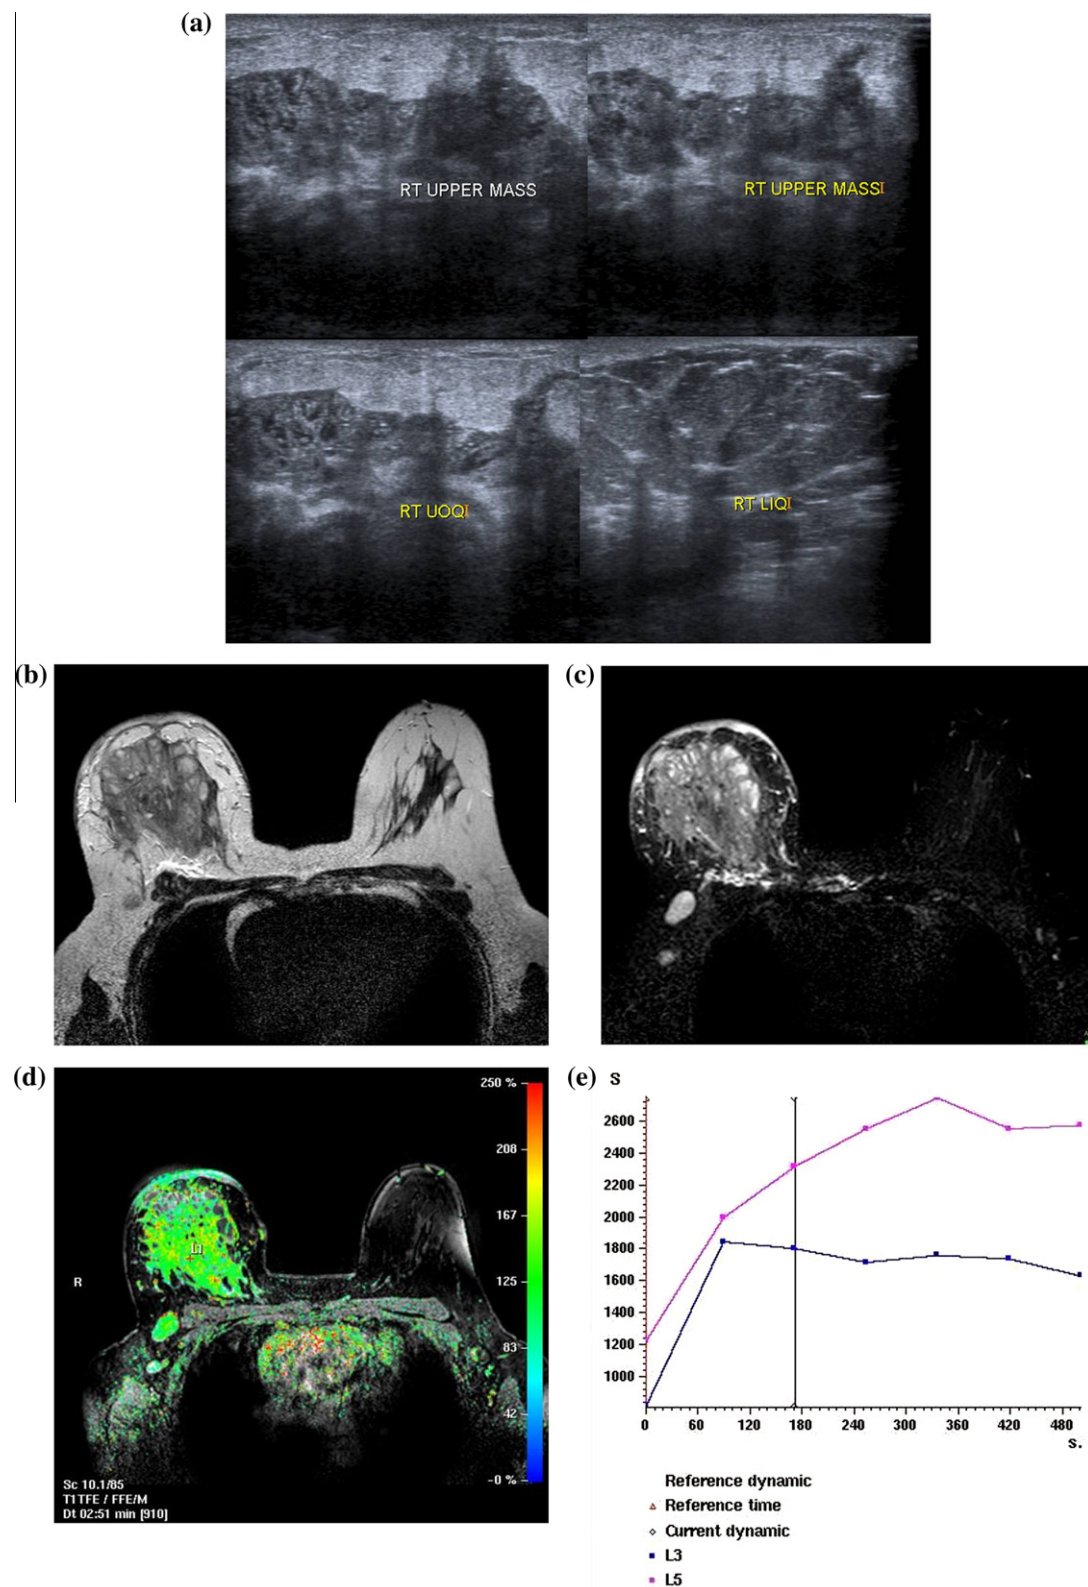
Right breast non-specific granulomatous mastitis. (a) Gray-scale US image shows false impression of soft tissue infiltration. Axial (b) T2-weighted and (c) T2 STIR images show the breast is studded with multiple variable sized complicated cystic spaces mingled with diffuse tissue infiltration of intermediate-high SI. Note right diffuse skin thickening, peri-pectoral edema and ipsilateral axillary enlarged node. (d) Axial THRIVE image 3.3 min post contrast with color overlay shows intense enhancement of the breast infiltration and marginal enhancement of the associate cystic spaces. Note faint insignificant skin enhancement. (e) Time/SI analysis shows early peak of contrast uptake at 89sec. with corresponding SI% of 126% and type III (early wash out) curve pattern.
